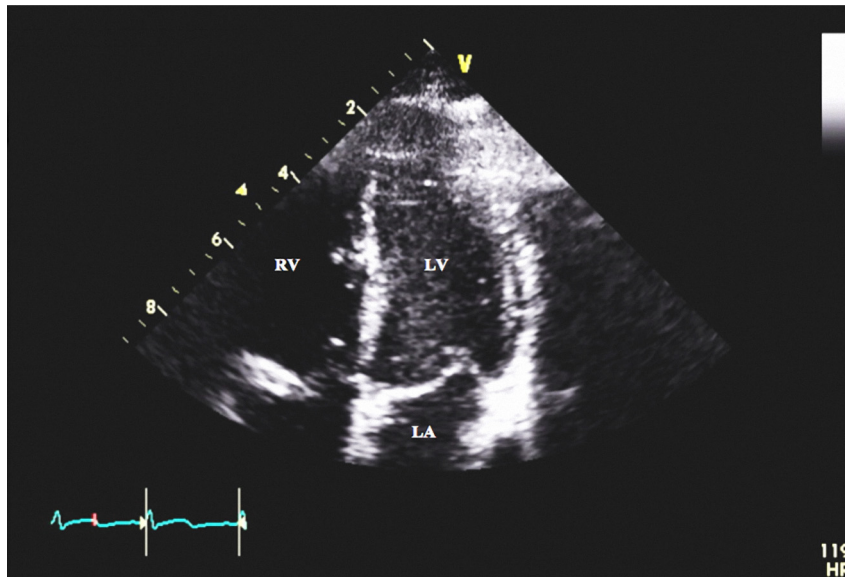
Four chamber echocardiographic view during systole shows the left ventricle has a normal contour and the earlier apical ballooning has improved.
